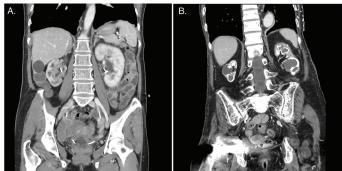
(A) CT of GUTB in right kidney shows infundibular stenosis with calyceal dilatation, renal scarring and cavitation, and solid lesions in parenchyma. (B) Over time, disease can progress to worsening infundibular strictures with papillary necrosis and significant scarring and calcification in both kidneys.
